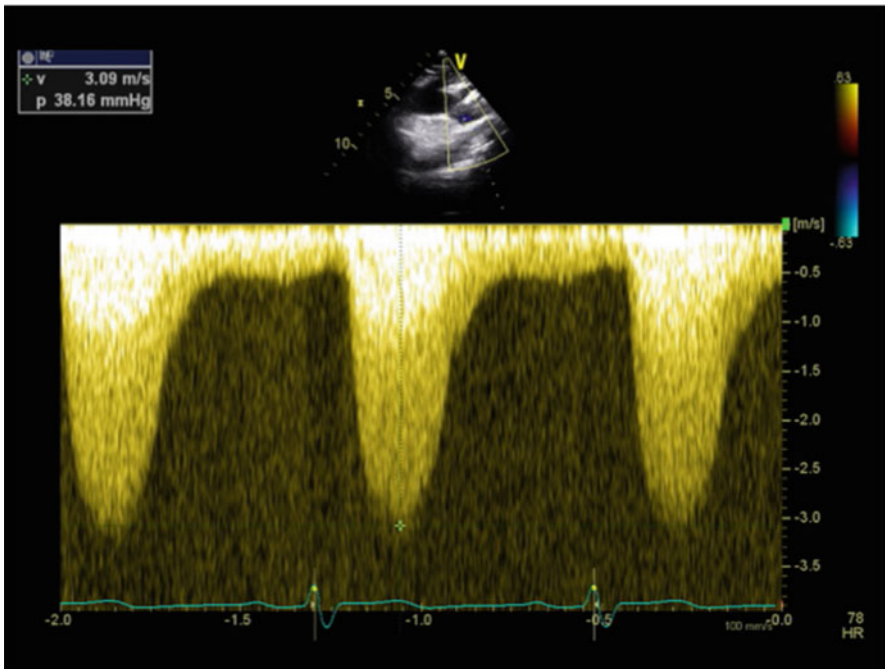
CW Doppler of a patient with CoA demonstrating a peak gradient of 38 mmHg and a long diastolic tail with end-diastolic velocity of 0.5 m/s
